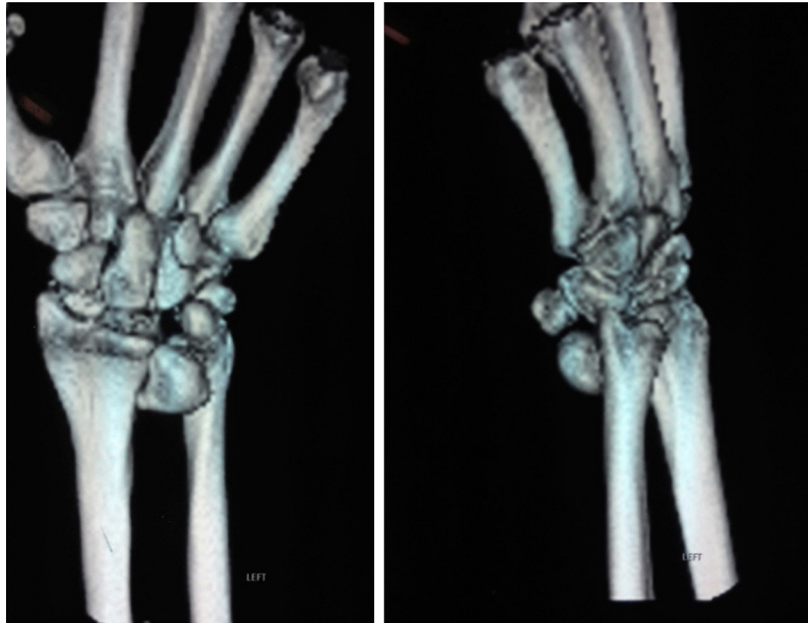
CT scan of the left wrist showing dislocation of lunate proximally on to the volar aspect of radius.
